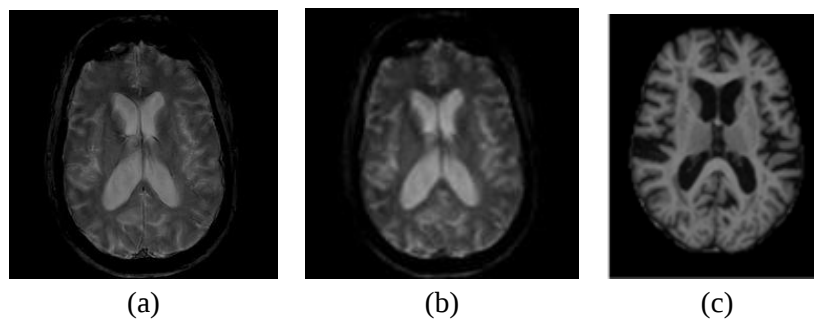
Comparison of Input MRI Images and Pre-processed Outputs using Fuzzy Clustering and Biased Fuzzy Clustering
